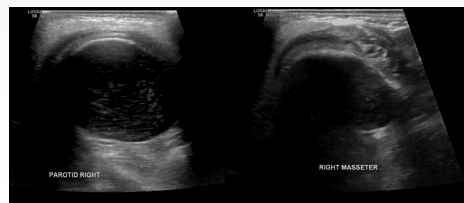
Ultrasound demonstrating a hypoechoic, avascular, well defined lesion deep to the masseter and accessory parotid gland. Evidence of cortical bony expansion and posterior enhancement, suggestive of a cyst within the ramus.
